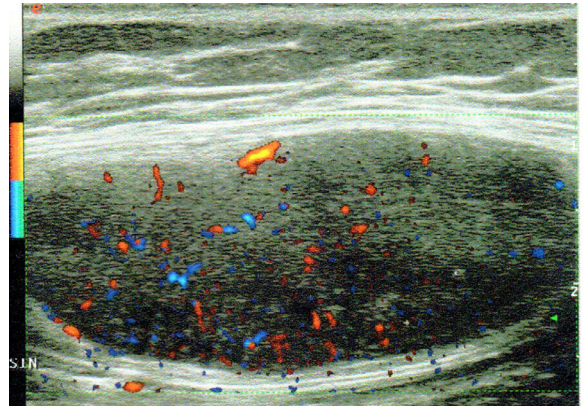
Color Doppler imaging revealed multiple small foci of vascularity scattered within a clearly defined, well-encapsulated, hypoechoic lesion located in the left thigh’s muscle.
